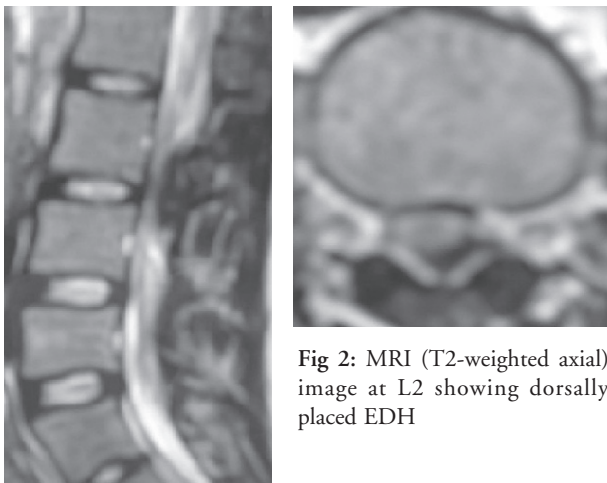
MRI (T2-weighted sagittal) image showing dorsally placed EDH
